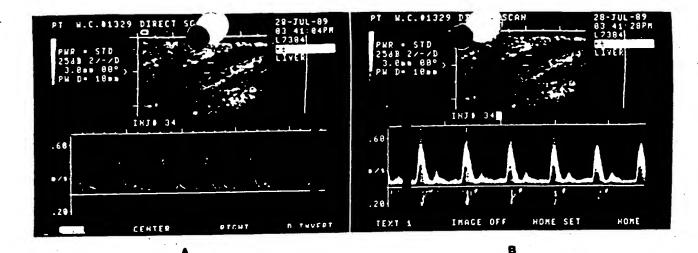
Spectral Doppler enhancement with Albunex. Sagittal image of the woodchuck aorta, A, before, and B, after the intravenous administration of 0.2 ml/kg Albunex shows marked of the septral Doppler signal intensity.
